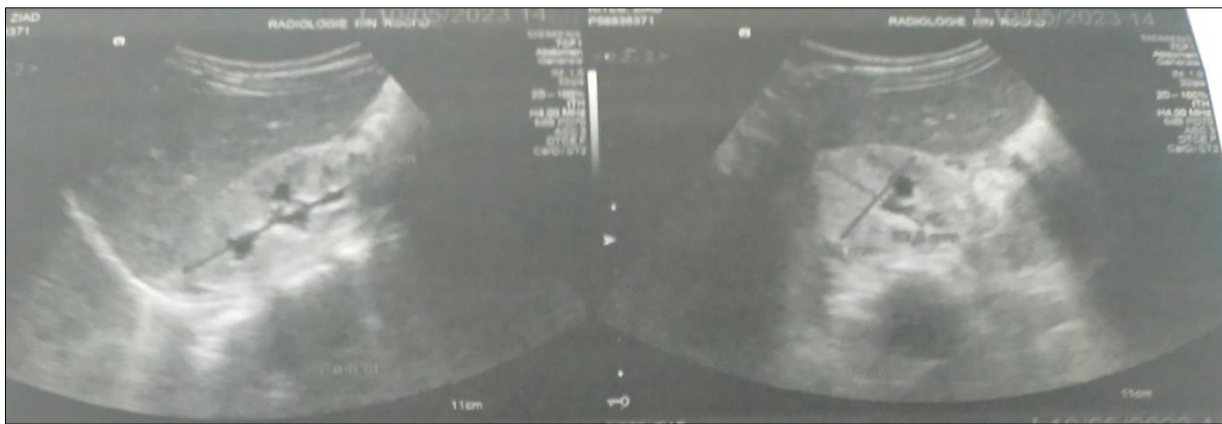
Right renal ultrasound showing an appearance in favor of chronic kidney disease: the right kidney is slightly reduced in size with regular contours and echogenic cortex, moderately differentiated measuring= 60 × 32 × 35 mm.
